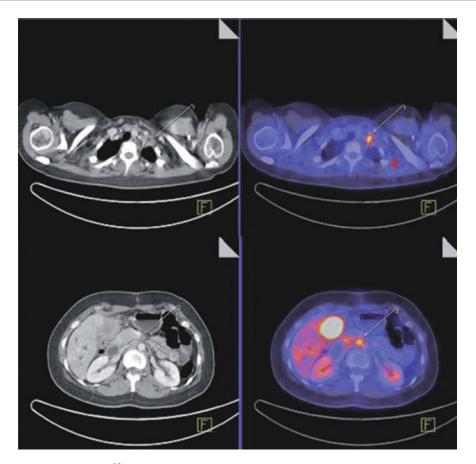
An example of an [¹⁸F]FDG PET/CT which showed evidence (positive finding) of disseminated disease (*arrow*) in a patient who was diagnosed with an incidental gallbladder carcinoma after cholecystectomy
